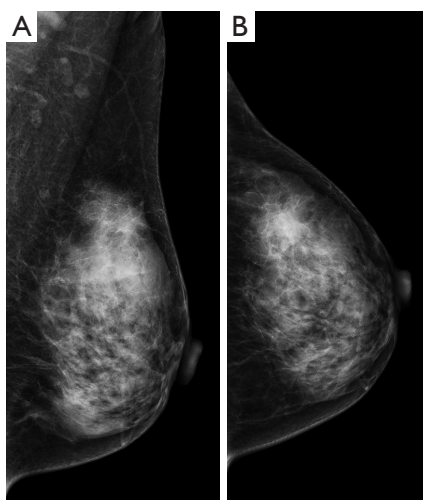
Radiographic examination results. (A,B) The mammography showed a high-density mass with obscured boundaries: (A) mediolateral oblique view; (B) craniocaudal view.
